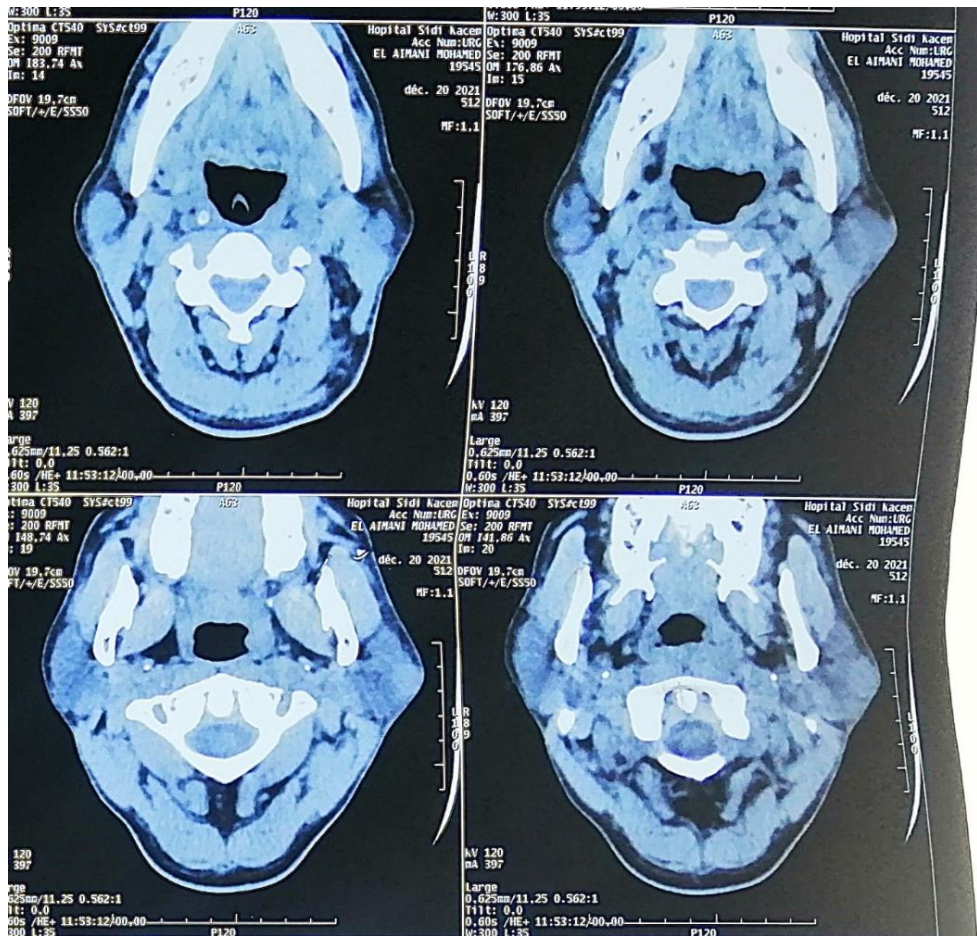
CT scan demonstrating necrotic cervical lymphadenopathy
